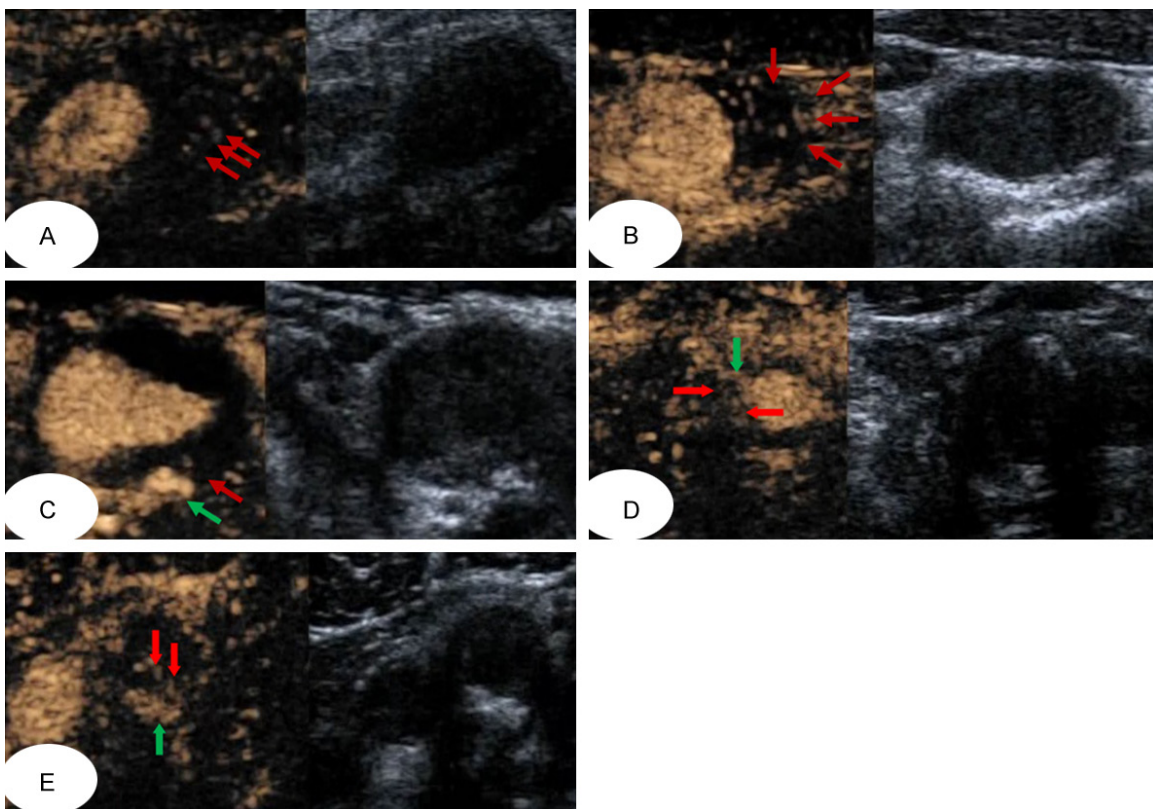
Representative contrast-enhanced ultrasound images showing different locations of plaque calcification. (A) Is a 60-year-old man. The red arrows point to enhancement near the base of the plaque in the bifurcation of the left carotid artery, which is grade I with a small amount of enhancement. (B) Is a 69-year-old man. The red arrows point to enhancement between the base of the plaques near the intima of the plaques, which was grade II with a large number of enhancements. (C, D) Are a 63-year-old man and a 60-year-old man respectively. The red arrow of (C) points to a small amount of enhancement with calcification peripheral, the red arrows of (D) point to a large amount of enhancement with calcification peripheral, and the green of (C and D) point to calcification near the base of the plaque. (E) Is a 60-year-old man. The red arrows of (E) point to a large amount of enhancement with calcification peripheral, and the green of (E) points to calcification near the plaque surface.
